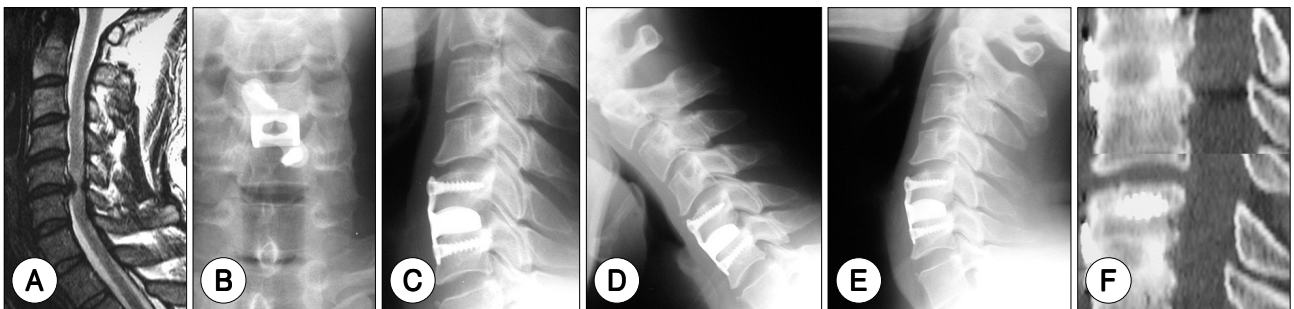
Representative images in a 46-year-old man with myelopathy and radiculopathy whom a PCB® was implanted in. A : In pre-operative sagittal T2-weighted magnetic resonance image, a herniated cervical disc at C5/6 is demonstrated. B and C : Postoperative antero-posterior and lateral X-rays showing an implanted PCB®. D and E : Flexion and extension plain X-rays nine-month after operation showing no instability. F : Nine-month postoperative computed tomographic study revealing the bone growth in the cage, and the sclerotic change and disappearance of the radiolucent line between the vertebral body and implanted bone.
